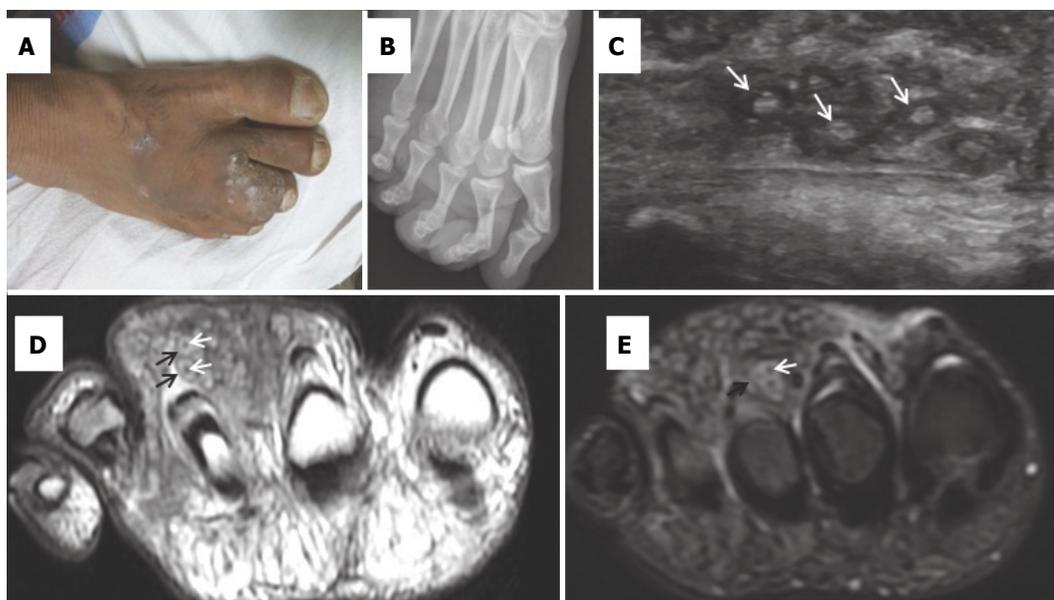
Eumycetoma of the foot. (A) Soft tissue swelling at dorsum of right middle toe and foot region with multiple encrusted skin sinuses. (B) Radiograph of the foot (AP view) appears normal except a soft tissue density shadow over heads of 2nd–4th metatarsals. (C) Ultrasound image shows multiple lesions (white arrows) with hypoechoic walls (circle) and hyper echoic foci in center (dots) giving the appearance of “dot in circle”. (D, E) Axial T2-weighted (D) and STIR (E) MRI images showing multiple hyper intense lesions with hypointense periphery (black arrows) with central hypointense dots (white arrows) giving the appearance of “dot in circle”.
